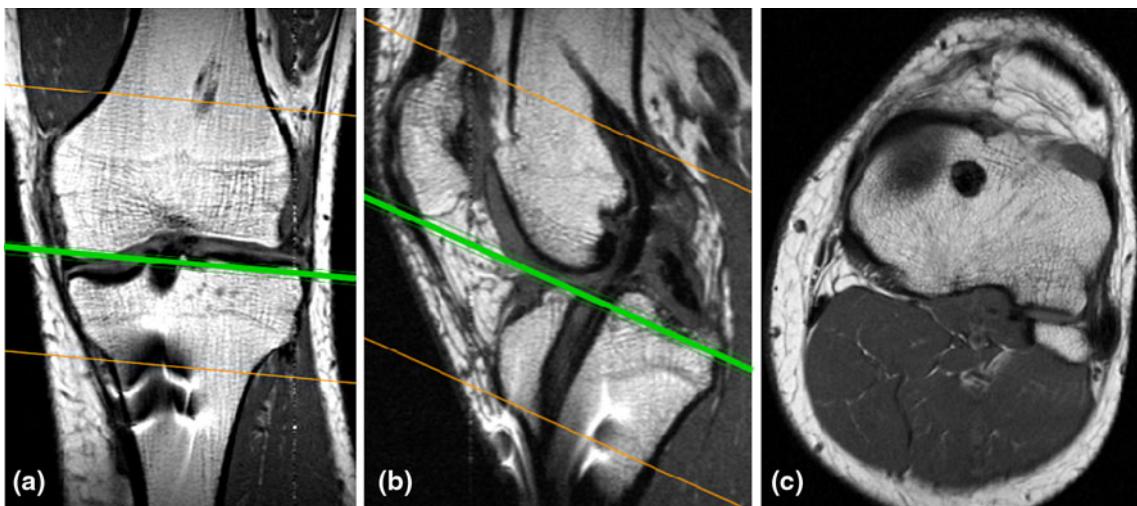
T1 MRI special transverse cuts strictly perpendicular to the axes of the bone tunnels were used to measure the diameters of the tibial and femoral tunnels. These special cuts were obtained using coronal and sagittal sequences as orientation. a Coronal sequence
